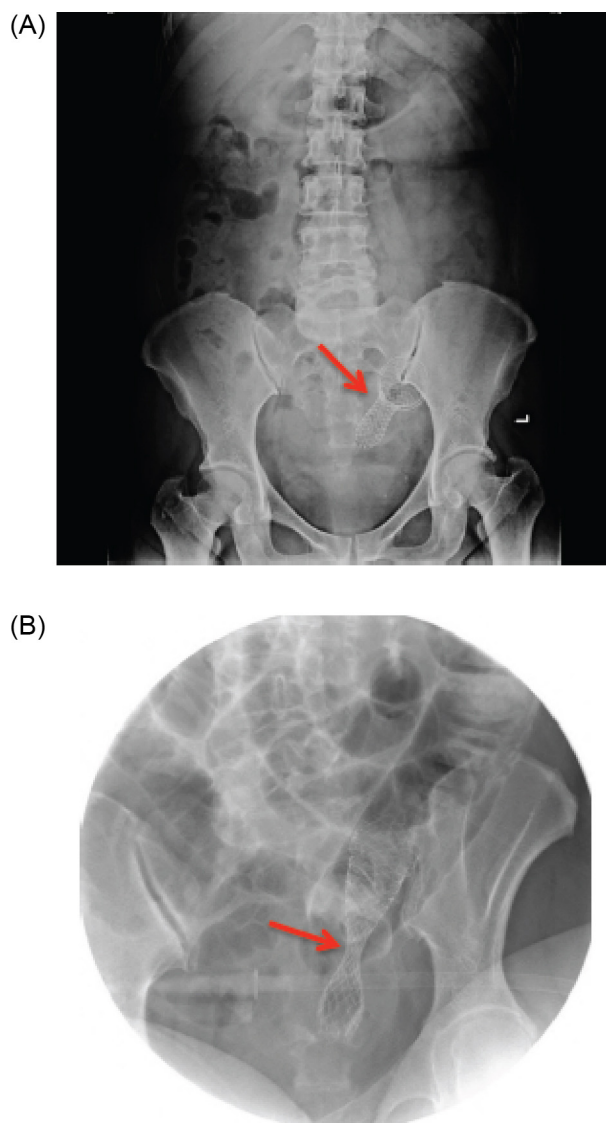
Abdominal x-ray. A: and B: After SEMS placement, plain abdominal film showed dumbbell-shaped metallic stent after deployment with no abnormal dilatation of the bowel (red arrow).
